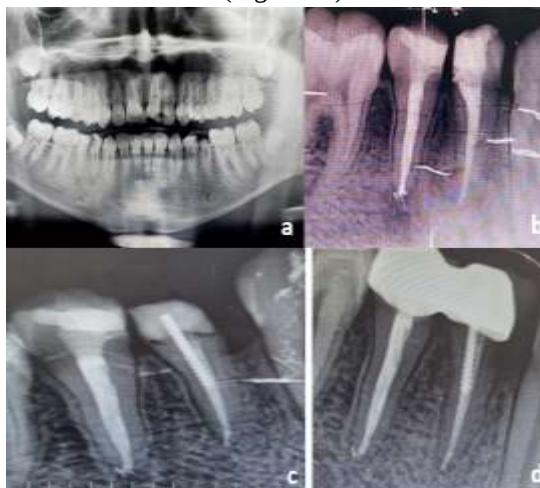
Pre-procedure radiographic view of Case 3 (a), after root canal repeat treatment (b), Post- cor application to tooth number 44 (c), and radiographic view after one year follow-up (d)
